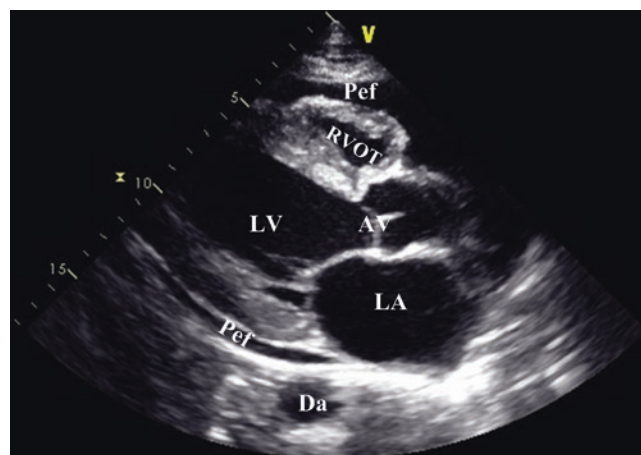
Pericardial effusion in the parasternal long axis view. In this view, the left atrium (LA), left ventricle (LV), right ventricular outflow tract (RVOT) and aortic valve (AV) are seen. Left ventricular ejection fraction is reduced. Pericardial effusion (Pef) appears as an echo free space around the heart, both anteriorly and posteriorly. Descending aorta (DA) allows differentiation of pericardial effusion from left pleural effusion: it is seen behind the echo bright pericardium. See also Video 18.1
